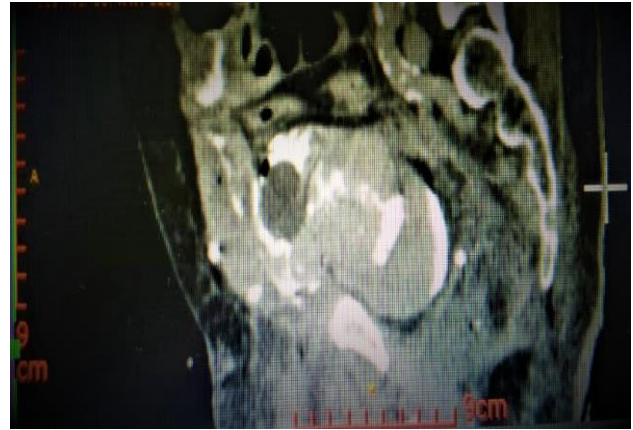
(Day 4 post operation CT imaging) contrast leak demonstrable from a defect measured 0.6 cm at right lateral wall of urinary bladder which was similar to the previously seen bladder defect; SPC's balloon seen outside the urinary bladder, located at perivesical space.
